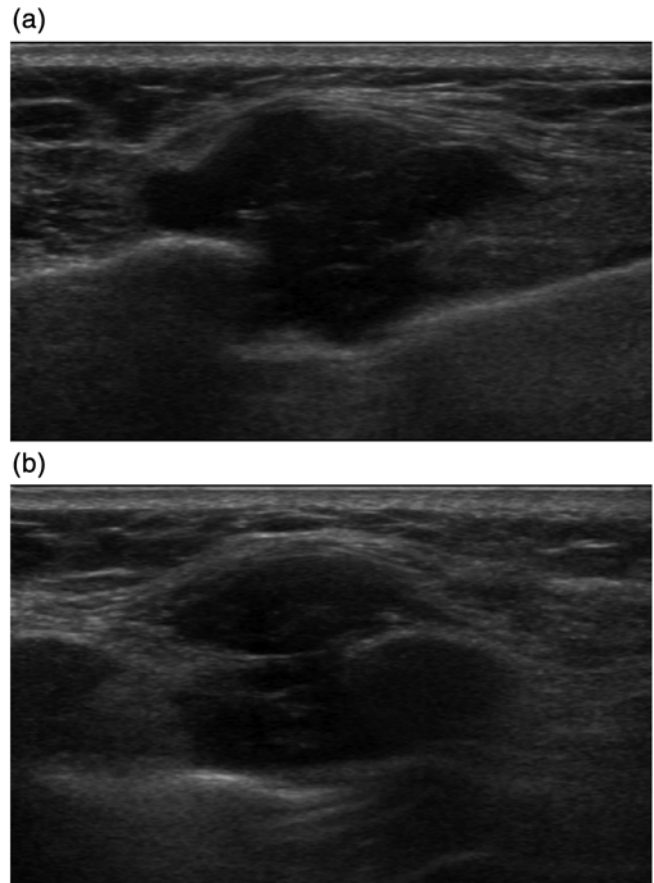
A 58-year-old woman with a palpable lesion after left mastectomy. (a) Transverse and (b) longitudinal sonography revealed a 28-mm-size hypoechoic nodule with irregular shape and speculated margin. This lesion was assessed as category 5, and US-guided core-needle biopsy was performed. Pathology results showed recurred invasive ductal carcinoma in both core biopsy and surgical excision
